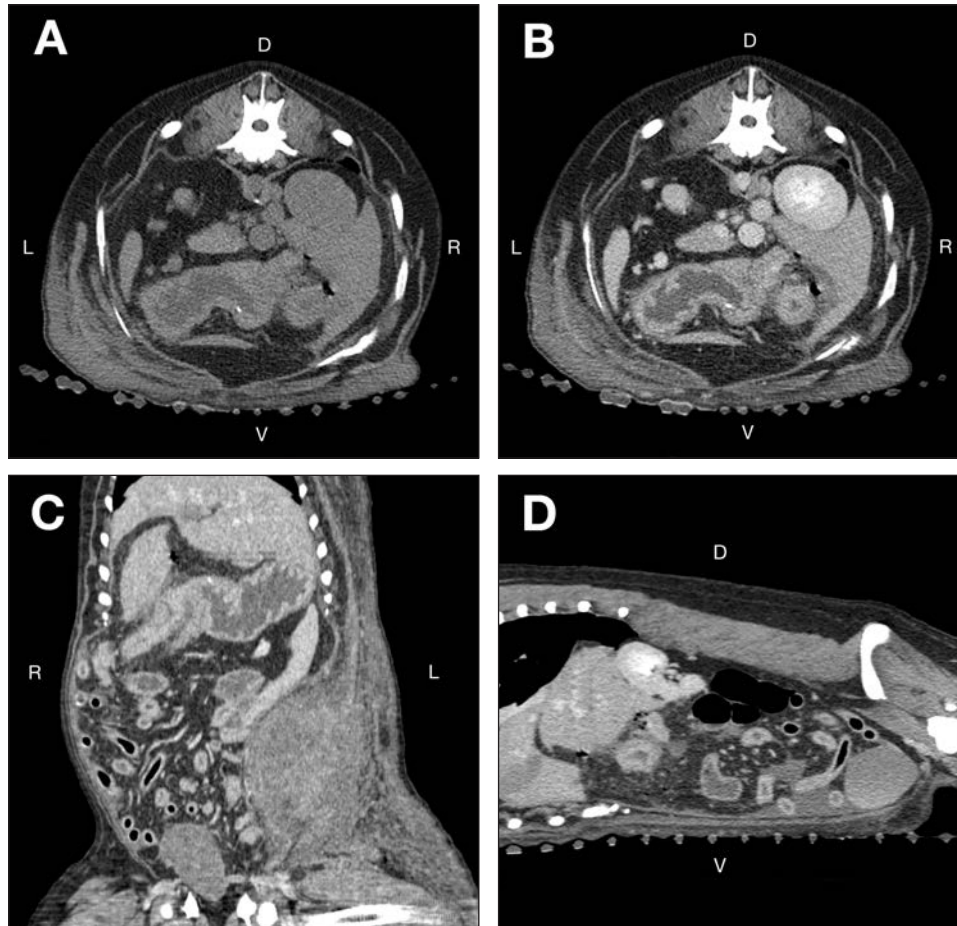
Transverse precontrast (A) and postcontrast (B) abdominal CT images at the level of the right kidney and reformatted postcontrast abdominal CT images in a dorsal plane through the ventral portion of the abdomen at the level of the body of the stomach (C) and in a right parasagittal plane through the right kidney (D) of a 9-year-old Golden Retriever evaluated because of lethargy, inappetence of 3 days' duration, and a body wall mass on the left side of the caudal aspect of the abdomen. Soft tissue settings were used for all images (window width, 400 Hounsfield units; window level, 40 Hounsfield units). D = Dorsal. L = Left. R = Right. V = Ventral.
